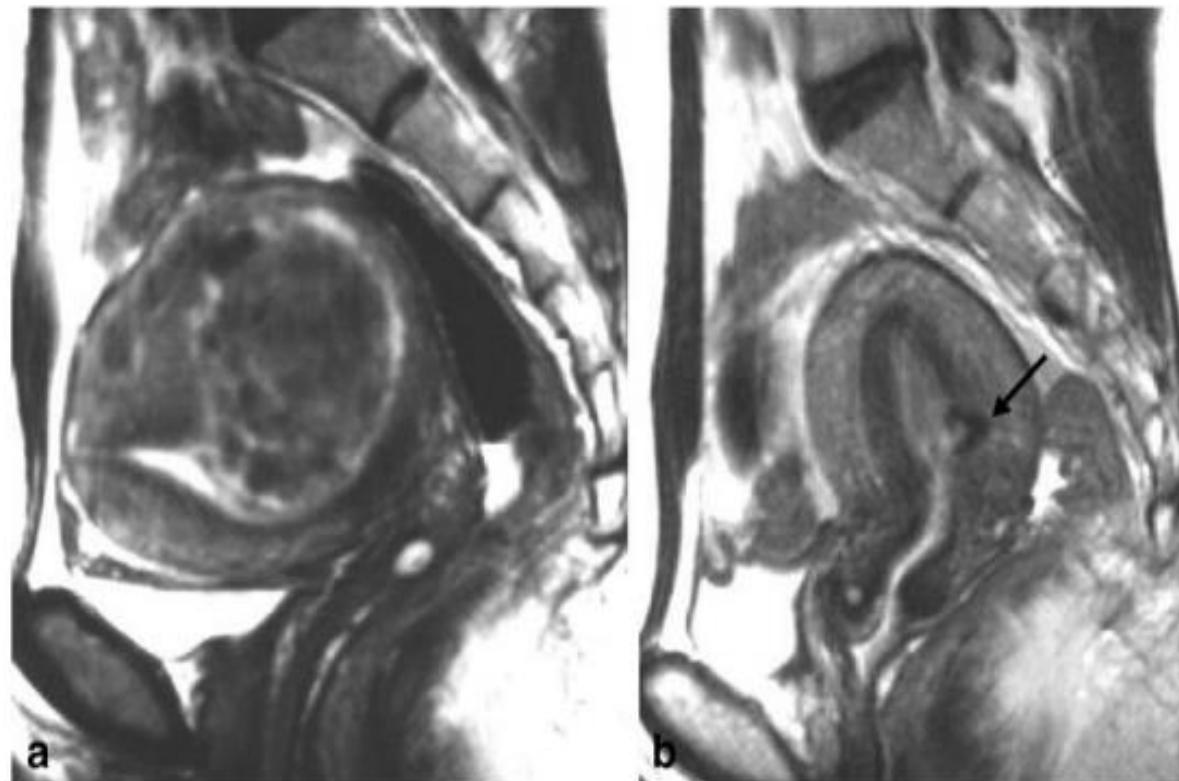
A 32-year-old woman with a pedunculated myoma. The T2-weighted image (a) shows a 5-cm pedunculated myoma (arrows). After UAE, the myoma disappeared 7 days later (b)
